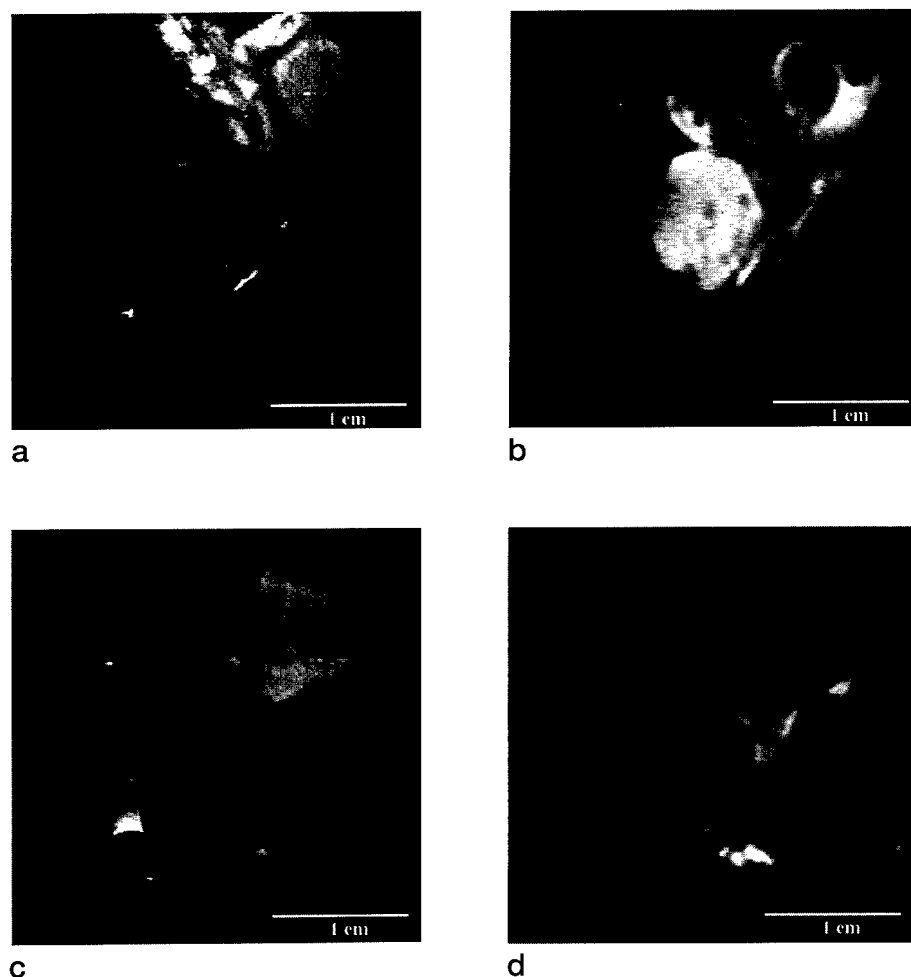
Representative MR images from implanted breast tumors. (a)  $T_2$ -weighted image of a 4-week-old MCF7 tumor (M3) with 128 phase encodes. (b) Diffusion-weighted image of tumor M3 with  $b = 636 \text{ s/mm}^2$  and 64 phase encodes. (c) A  $T_2$ -weighted image of a 4-week-old T47D tumor (T5) with 128 phase encodes. (d) Diffusion-weighted image of tumor T5 with  $b = 636 \text{ s/mm}^2$  and 64 phase encodes.
